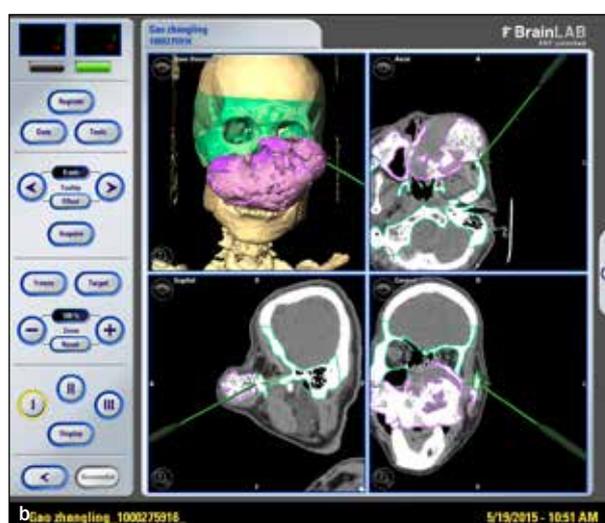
Virtual preoperative design. (a) Preoperative views of facial appearance. (b) CT shows the tumor. (c) The fibular free flap is designed. Subsequently, virtual implants are placed that help in repositioning the fibular free flap.
